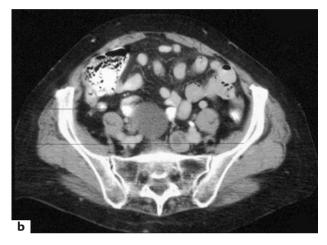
(a) and (b) Computed tomography (CT) scan reveals a necrotic metastatic lymph node
